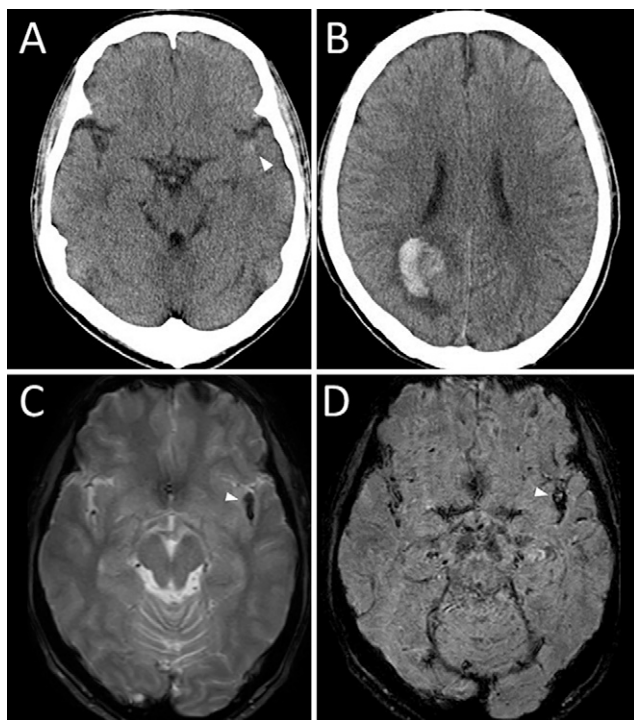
Computed tomograms on admission showing subarachnoid hemorrhaging (arrowhead) in the left Sylvian fissure (A) and intracerebral hematoma in the right occipital lobe (B). T2-weighted fast field echo magnetic resonance image showing a low signal intensity area, suggesting hemorrhage in the left Sylvian fissure (arrowhead) (C). Susceptibility-weighted (SWI) magnetic resonance image showing a high signal intensity area within a low signal intensity area, suggesting an ruptured aneurysm with subarachnoid hemorrhage (arrowhead) (D).
